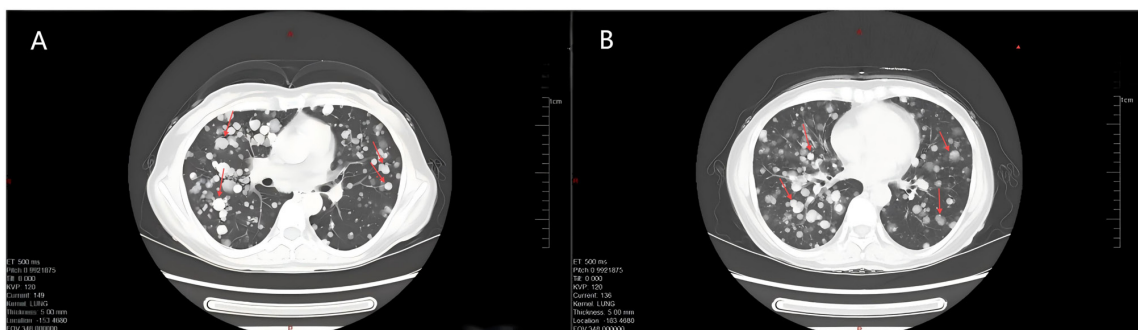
Multiple metastases shown on chest CT (arrows indicate the lung metastasis focus). (A) Level below the carina of trachea 1. (B) Level below the carina of trachea 2.
